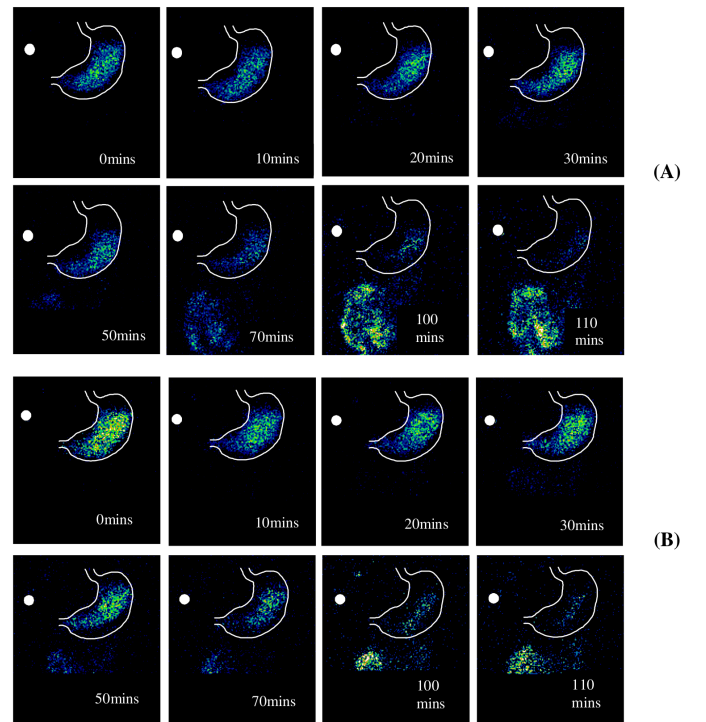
A series of scintigraphic images for subject 3 showing up to 90% gastric emptying. (A) shows images in the control arm of the study and (B) shows images from the GTN/Vit C arm.
